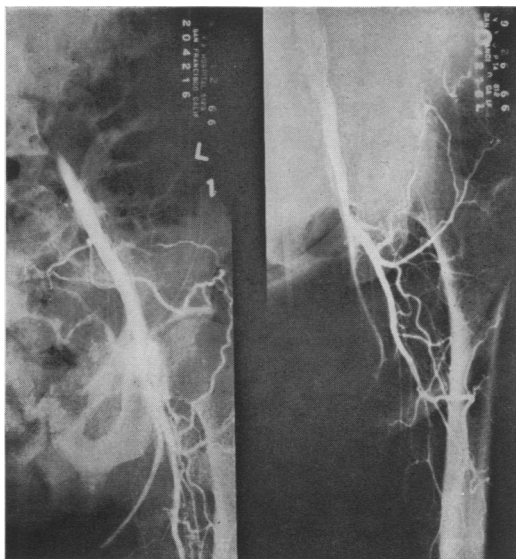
(Left) Arteriogram demonstrates a false aneurysm at the anastomosis of a Dacron graft to the left common femoral artery. (Right) Radiographic appearance following false aneurysm excision.
